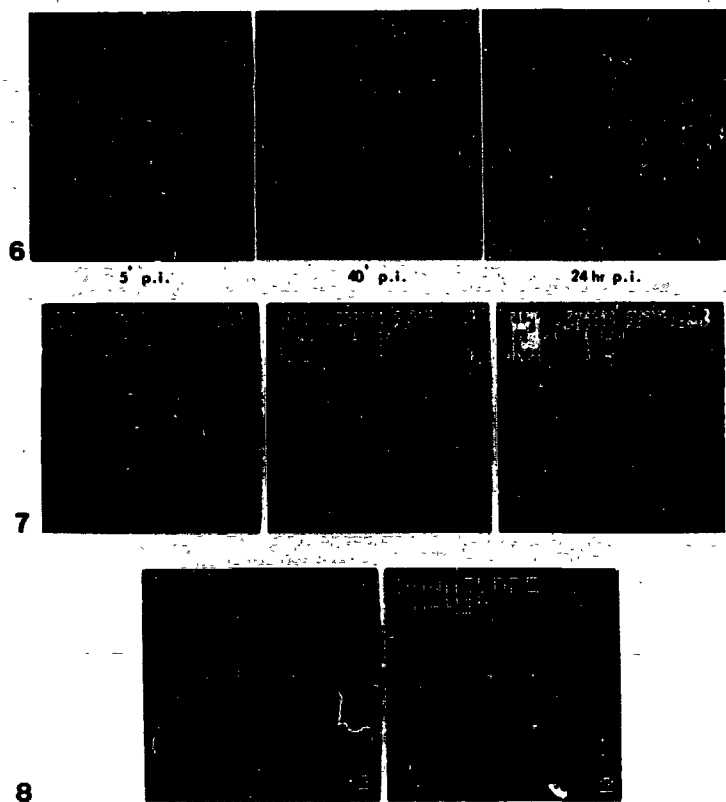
6-8 Cholescintigraphy in a patient with bile duct obstruction due to pancreas head tumour.
